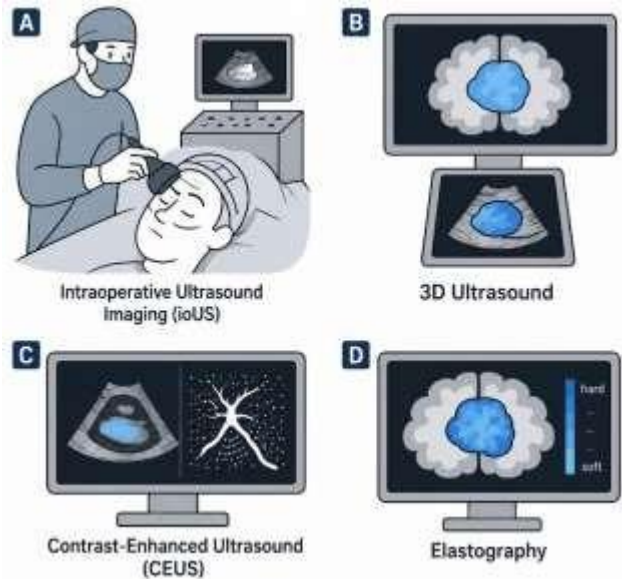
Modern technologies of intraoperative ultrasound (ioUS)
